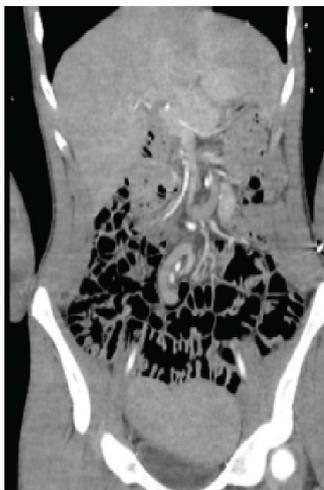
CT showing the spleen within the pelvis.
